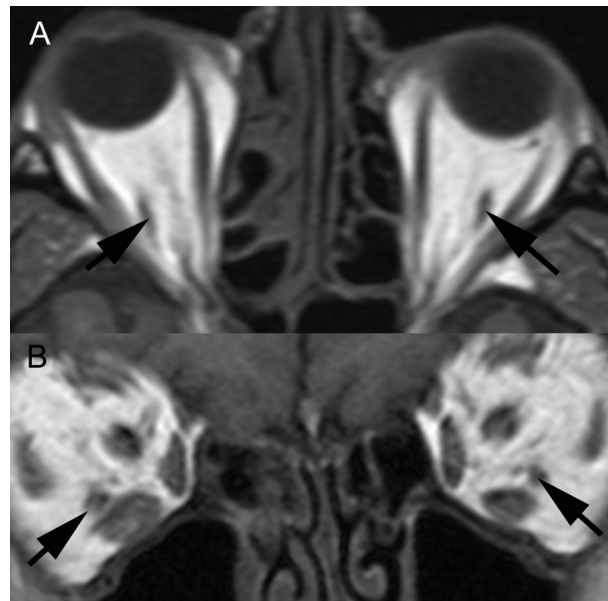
T1W axial and coronal magnetic resonance images. The accessory extraocular structures in both orbits are shown (arrows).
